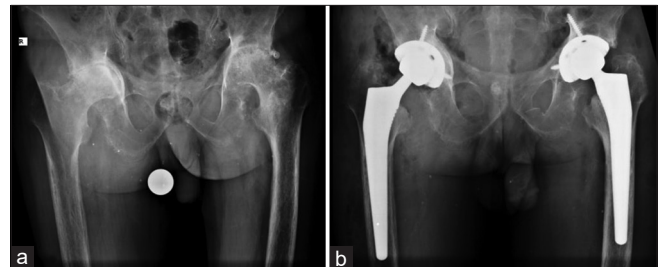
(a) Preoperative anteroposterior radiograph of the hips (b) Postoperative anteroposterior radiograph of the hips
